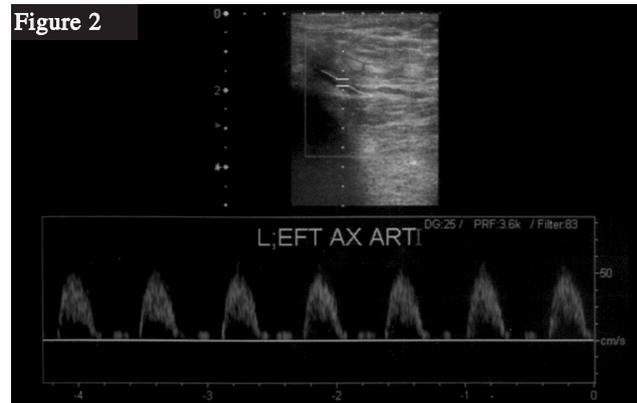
Monophasic, low amplitude flow in all arteries (from axillary artery to radial and ulnar arteries) of left upper extremity and triphasic, high amplitude flow in all arteries (from axillary artery to radial and ulnar arteries) of right upper extremity in the power Doppler examination
